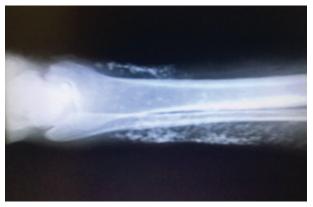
Right and left ankle radiographs showing hypertrophic ossification
